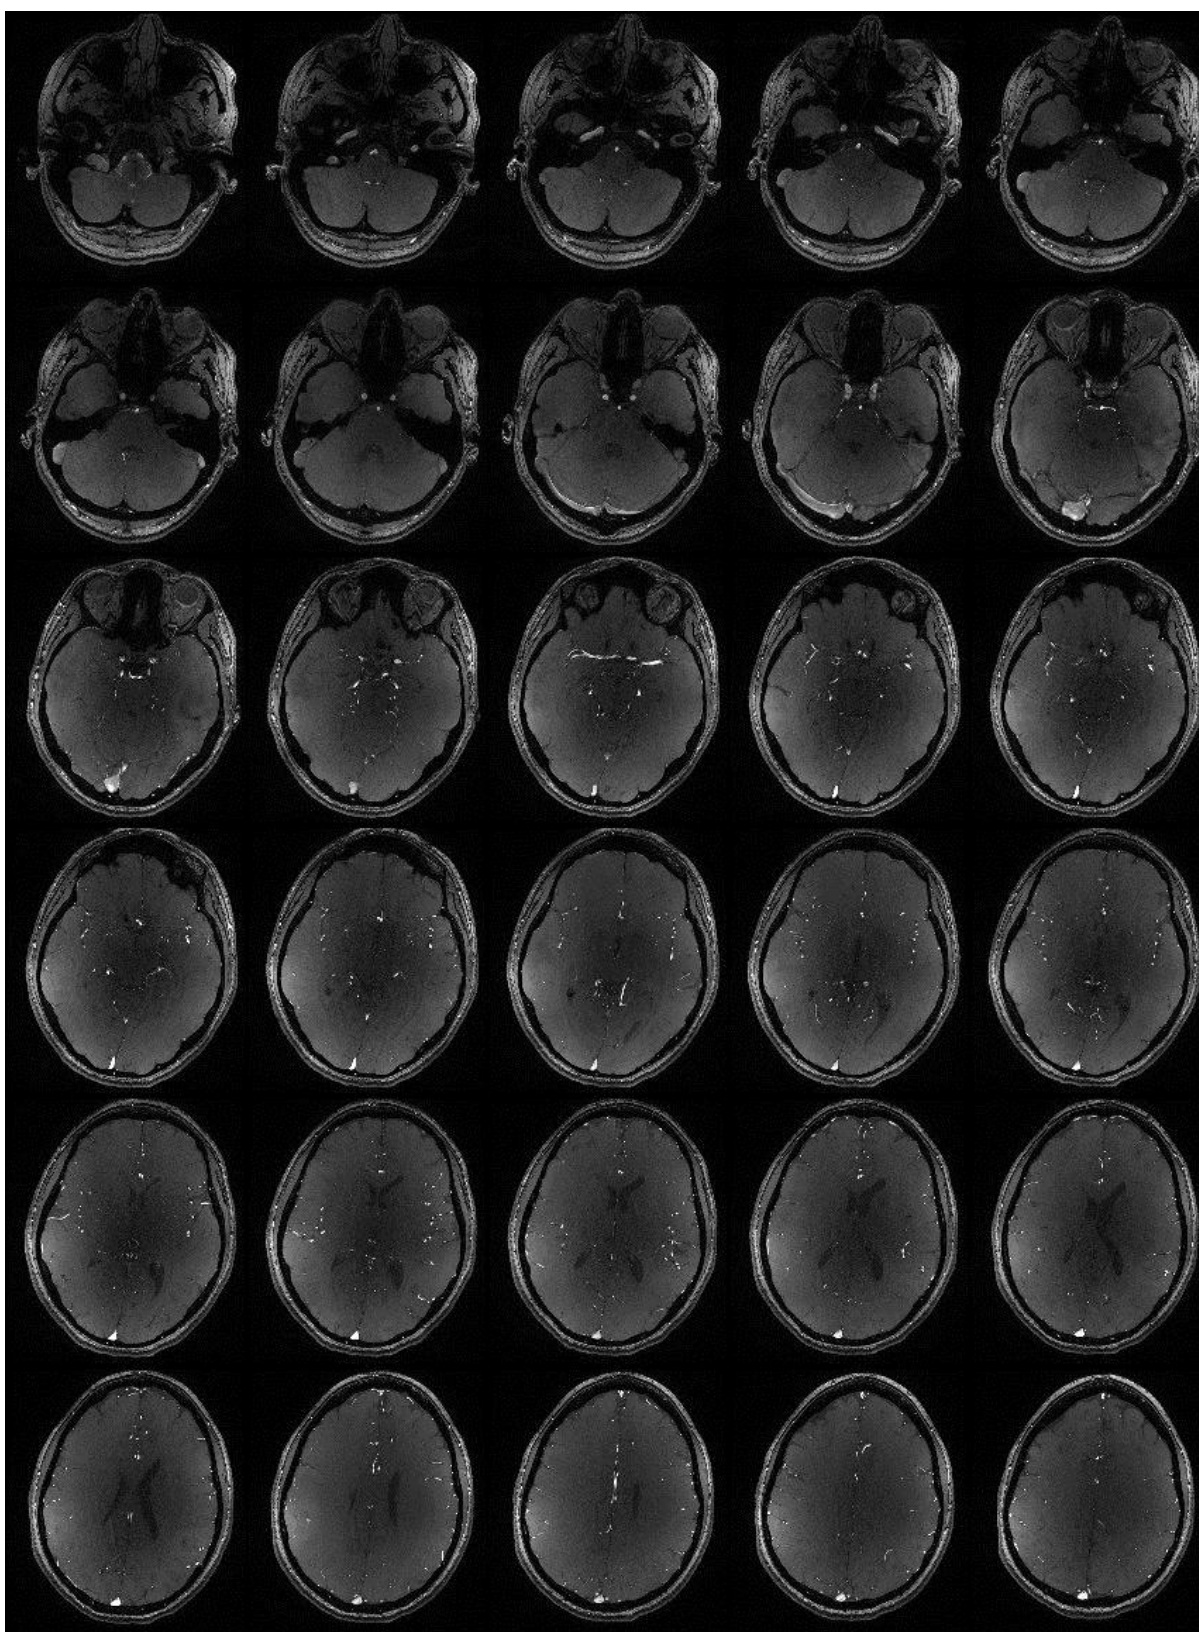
Figure B-4. MRI montage image of normal subject 4
